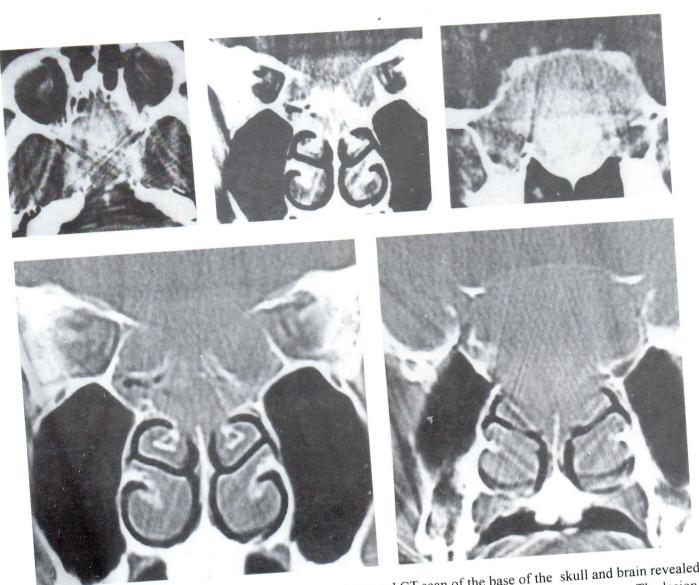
Case 4. Non contrast enhanced CT scan of the brain and base of the skull in axial view showed a hyperdense soft tissue in the sphenoid sinus.
